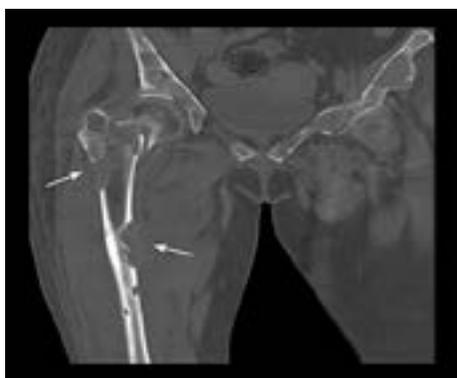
Computed tomography image of the right femur reveals a cortical osteolytic expansile lesion in the middle and proximal aspect of the right femur, with bulging of surrounding soft tissue and a femoral neck fracture
